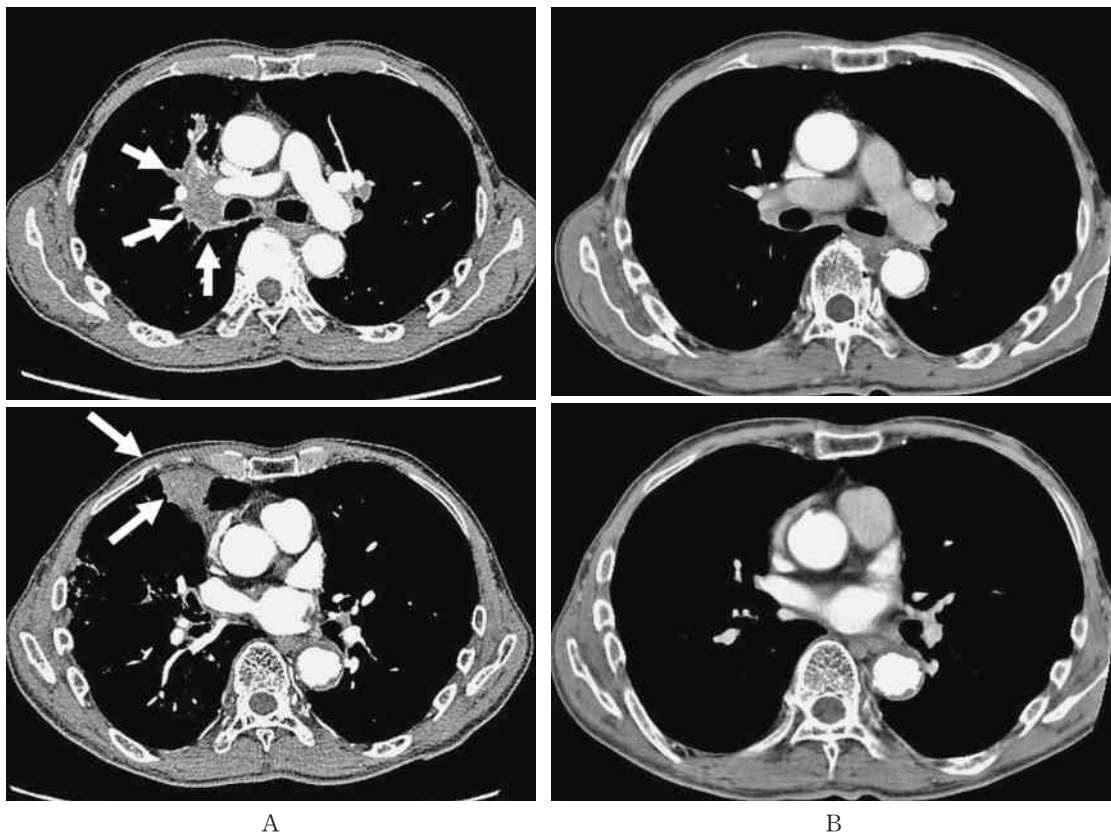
Chest computed tomography before (A) and after (B) S-1 mono-chemotherapy. A; before chemotherapy, swelling of right hilar lymphadenopathy and mass in right upper lung fields. B; three years after S-1 monotherapy. The lymphadenopathy and mass have disappeared after S-1 mono-chemotherapy over three years (B).
